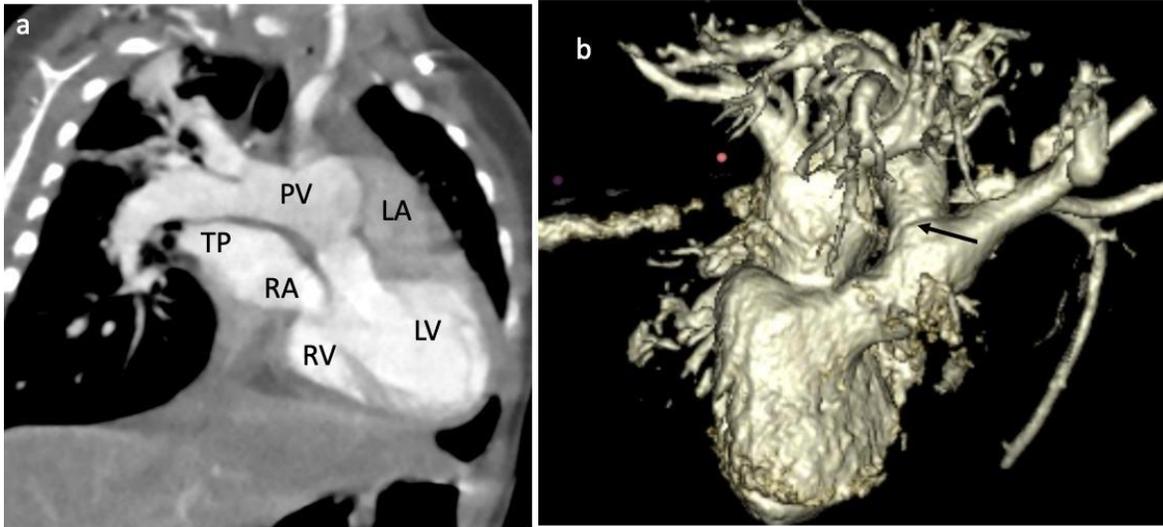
CTA of 4-month-old baby boy, (a) the septum ventricles is intact. (b) 3D image shows the connection of sinotubular junction of aortic and MPA (black arrow). The findings above are according to the Type A of IAA accompanied with the AP window and PDA from the MPA to the descending aorta without septal defect.
